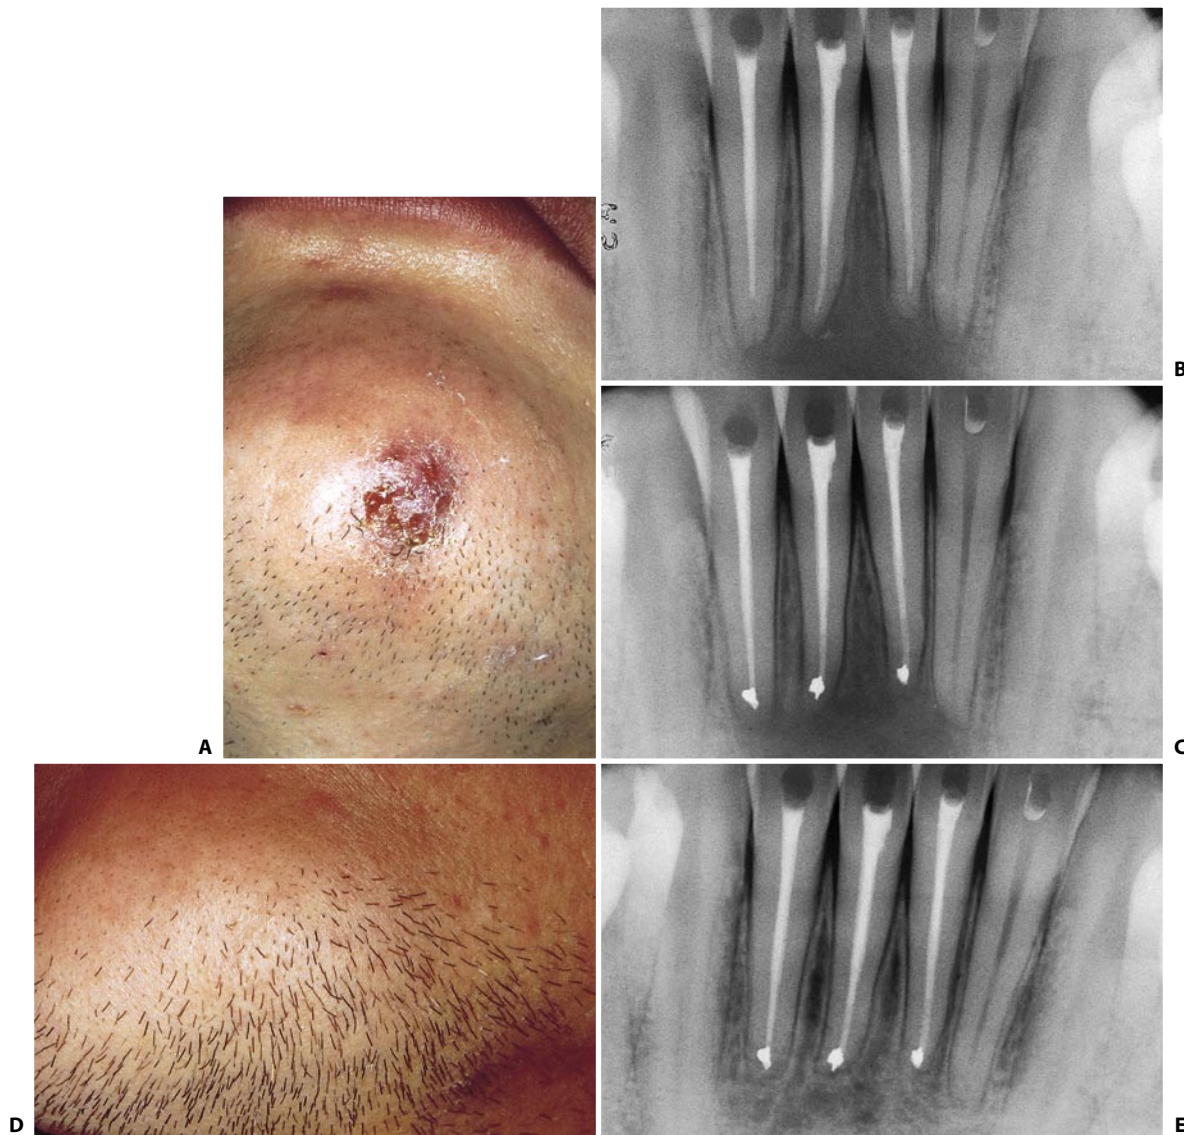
A. Cutaneous fistula in the mental region. B. Preoperative radiograph of the lower incisors. The patient elected surgical therapy for economical reasons. The left lateral incisor had already been subjected to a cavity test. C. Postoperative radiograph. Three apicoectomies with amalgam retrofilling have been performed. *Not the least attention has been paid to removal of all the granulation tissue or to curettage of the surrounding bone or apices, or to removal of the fistulous tract, or even to circular incision of the cutaneous orifice of the fistula.* D. Complete healing of the cutaneous fistula without any residual scarring after two years. E. Radiograph two years later confirms total resolution of the previous radiolucency.
